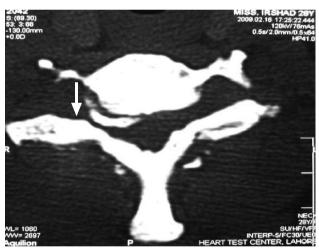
Axial view of CT scan cervical spine showing ossification of PLL.
